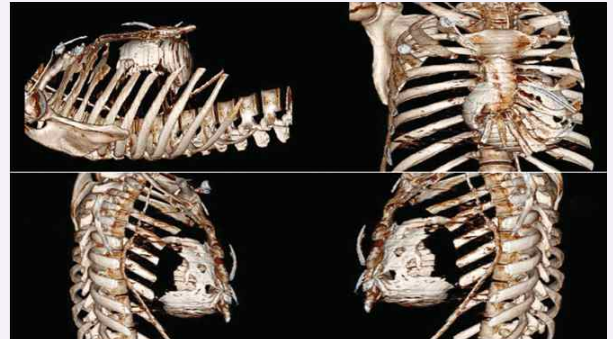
Three-dimensional reconstruction from CT thorax showing the calcification of pericardium
